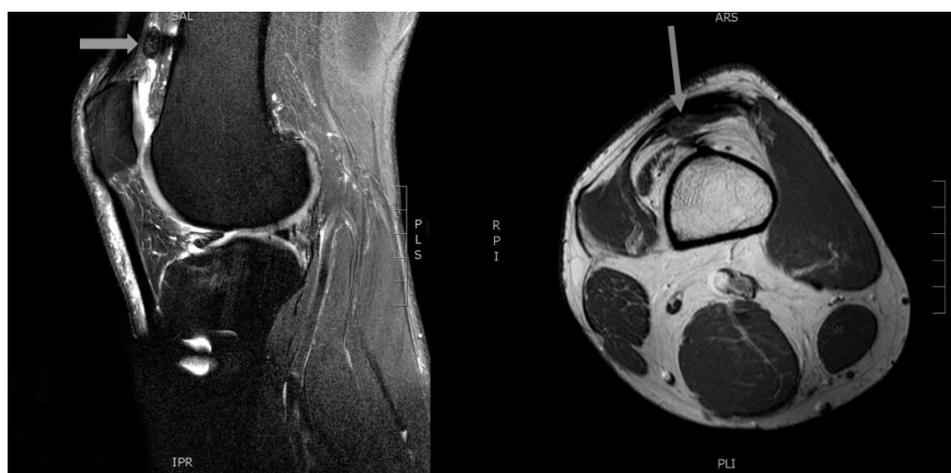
Sagittal and axial MRI (T2-weighted, with fat suppression and T1-weighted, with contrast enhancement respectively), with the arrow indicating the PVNS nodule in the suprapatellar recessus. Note the subtle metal artefact of the underlying button. (October 2015).
